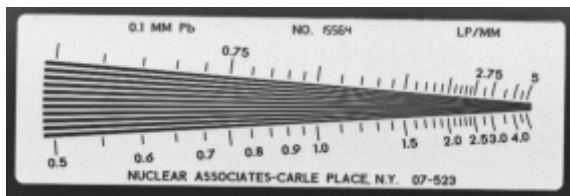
X-ray bar pattern used for the experiments.
